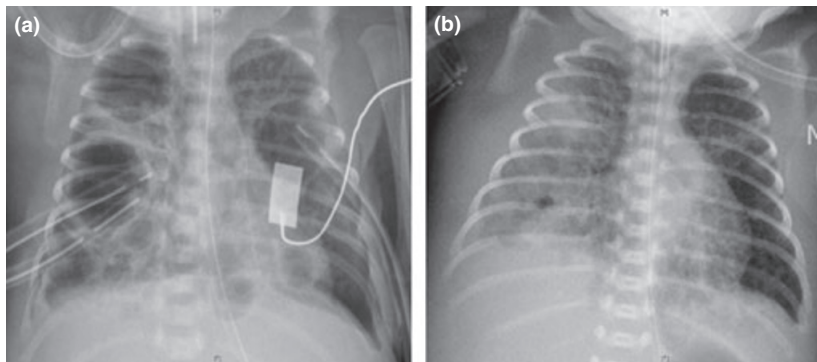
Chest radiographs of Cases 1 and 2. (a) Case 1: rapidly progressive necrotizing pneumonia. (b) Case 2: overwhelming sepsis.
